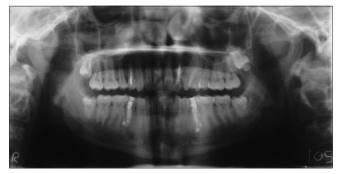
Panoramic radiograph (postoperative)
